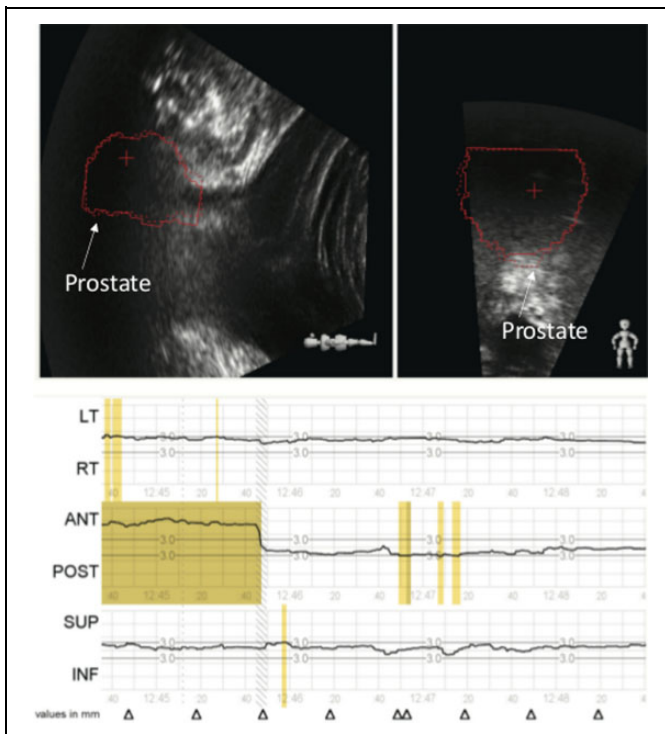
Prostate shift is identified by the Clarity Autoscan ultrasound system. The Clarity Autoscan ultrasound system shows an anterior prostate shift of 1 cm. The red prostate contour (solid line) has moved anterior to the zero position (red dotted line) by 1 cm as noted in the lower panel and maintains this position over several minutes. The red contour is contoured during the planning process on the planning computed tomography (CT) and transferred to the ultrasound (US) image during the registration of the 2 images in the Clarity system. On the first treatment, the contour is imported into the monitoring system.
